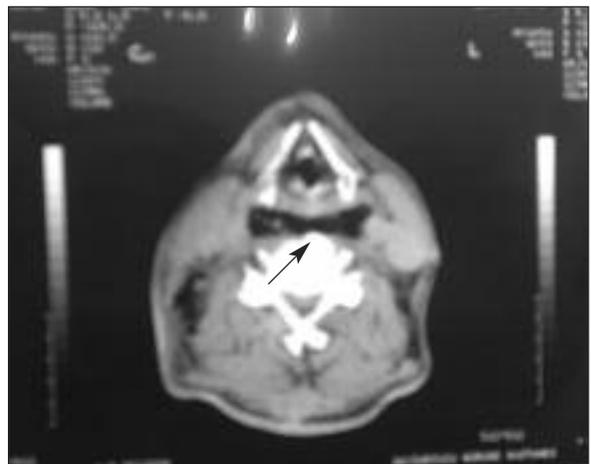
Cervical neck CT scan (axial):retropharyngeal air collection
